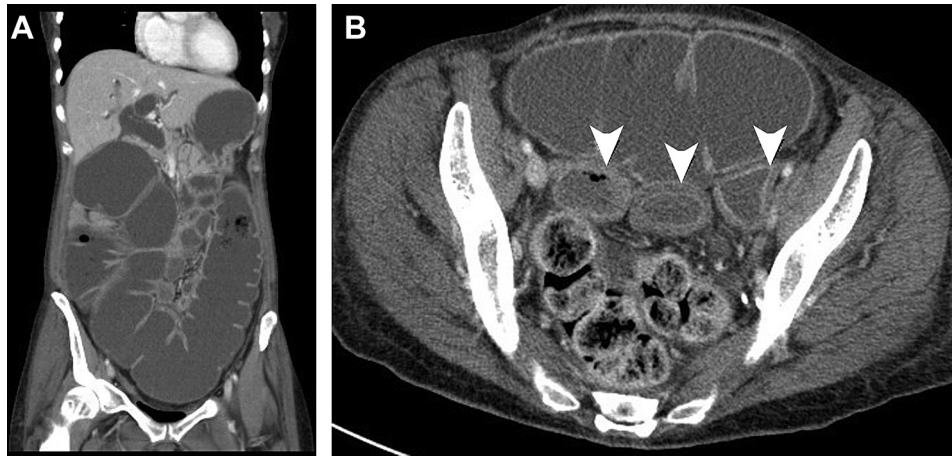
Computed tomography at presentation. (A) Coronal reconstructions show marked dilatation of the colon. (B) Axial images show thickening and striation of the sigmoid wall (arrowheads) with feces in the distal sigmoid and rectum.
